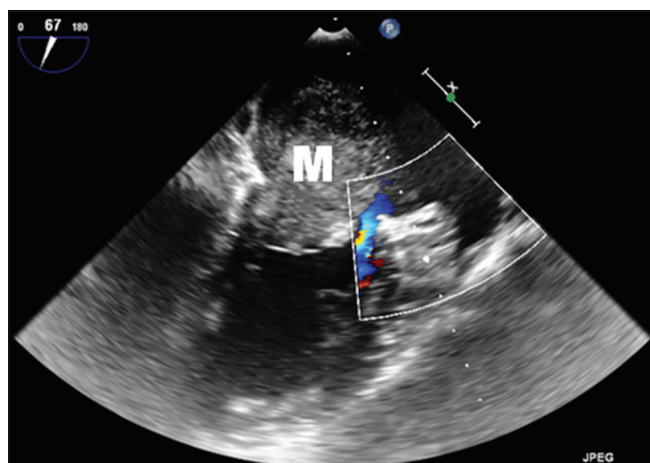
Transesophageal echocardiogram showing myxoma in the left atrium
